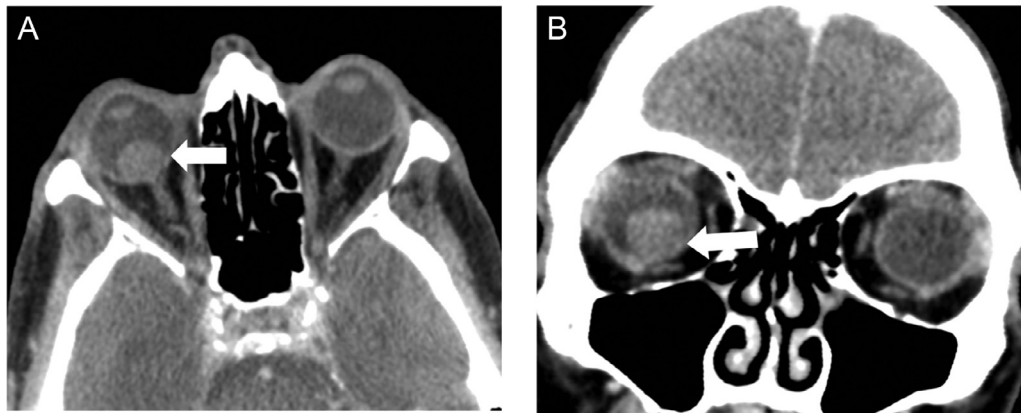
Patient 3. (A-B) Axial (A) and coronal reformatted (B) contrast-enhanced maxillofacial CT for an unrelated condition showed a mass centered in the inferomedial aspect of the right posterior globe (arrows), measuring 1.4 cm in greatest dimension.
